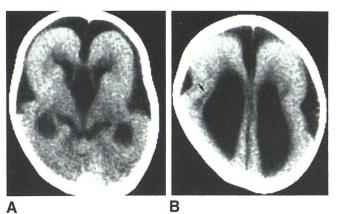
Case 2 (case 2 in [10]). Type I lissencephaly in MDS. A, CT scans at 3 years (A and, higher cut, B) are similar to fig. 1 except that no midline calcification is observed. Chromosome analysis was apparently normal. Smooth subsurface line (*arrow*).
